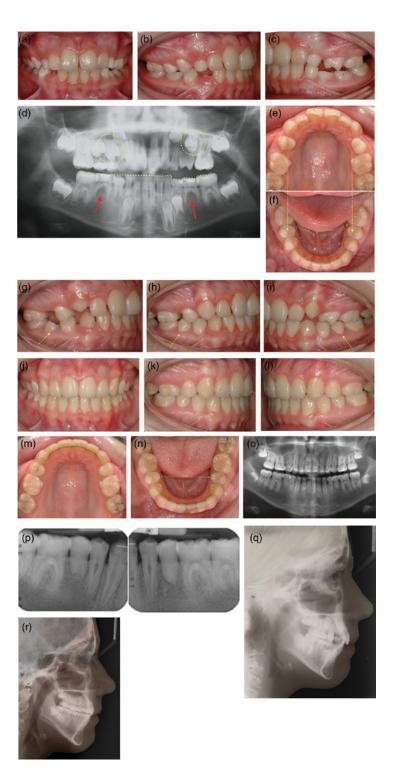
A 11y 5m girl was seeking orthodontic treatment (a–d). She had congenitally missing lower second premolars, detected on the panoramic radiograph (d, arrows). Infraocclusion of the primary molars on the left side was noted during her clinical examination. The patient's mother also had congenitally missing lower second premolars and she was concerned about the progressing infraocclusion of her daughter's teeth. Autotransplantation of unerupted upper second premolars (d, circles) was performed to replace missing teeth in the mandible (e, f, arrows). Eruption of the transplanted premolars and spontaneous correction of the dental relationships was seen after 12 months (g) and 18 months (h, i), when the orthodontic treatment was initiated. A stable occlusion and normal tooth contacts were present 1 year after debonding (j-n). No infraocclusion and hard tissue pathology was detected on the post-treatment radiographs (o, p). The patient's profile remained generally unchanged after the treatment (q: before the treatment, r: after the treatment).
